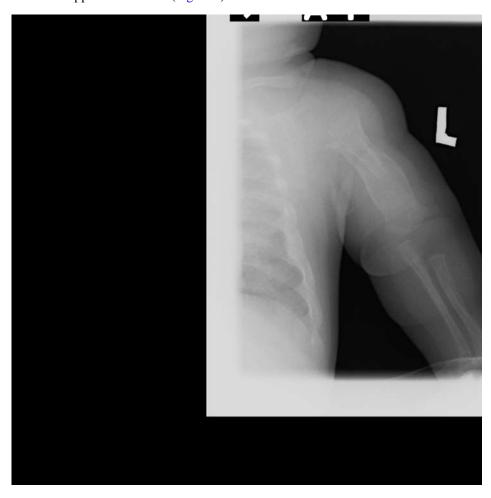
Control X-ray showed normal healing of the left humerus but still apparent bone loss
